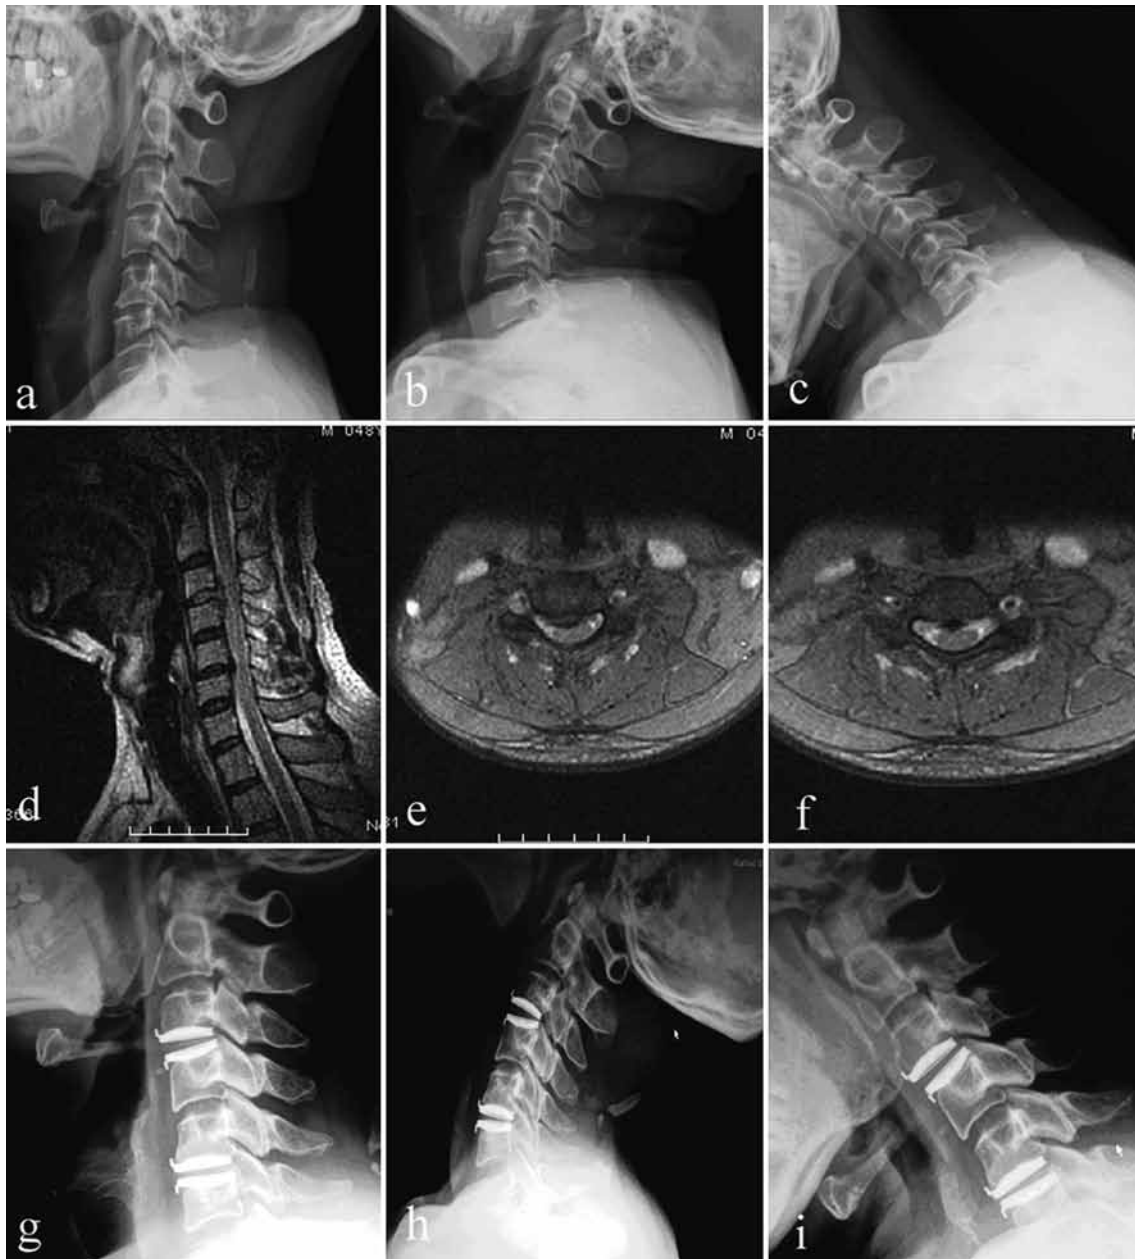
A 48-year-old man underwent a cervical disc replacement at C3C4 and C5C6. Top : preoperative neutral and flexion-extension radiographs showing initial mobility. Middle : preoperative MRI T2 reveals spinal cord compression secondary to disc herniation at C3C4 and C5C6. Bottom : 24 months postoperatively, neutral and flexion-extension radiographs demonstrate a restored range of motion without prosthesis excursion or subsidence.
